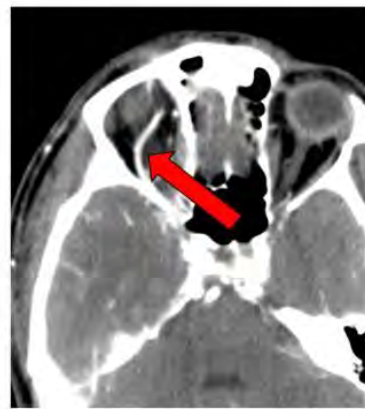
CTA of the head shows a unilaterally engorged right ophthalmic vein (red arrow) in a patient with carotid-cavernous fistula.
